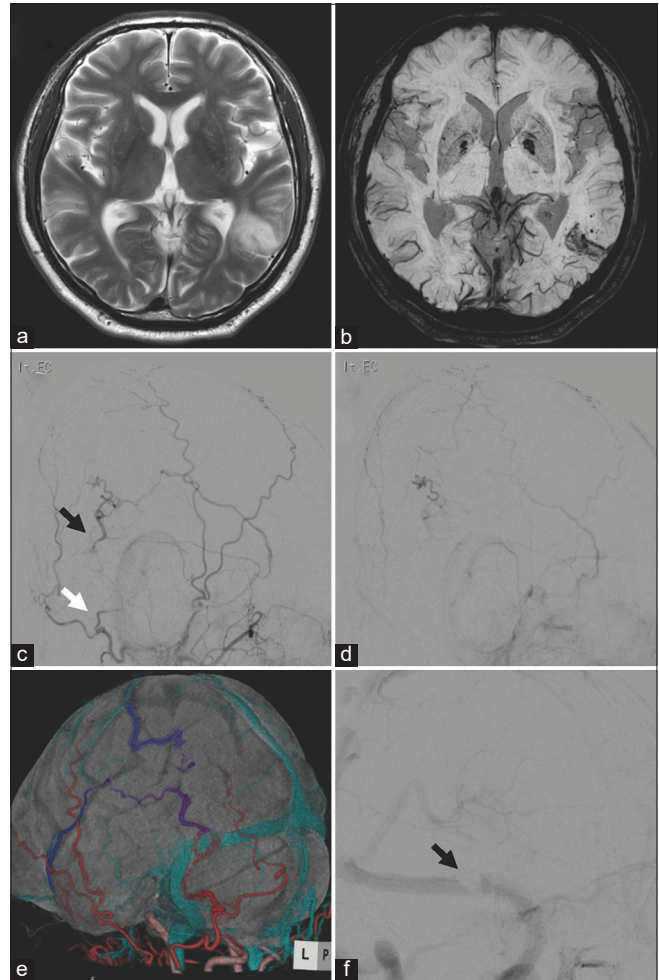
(a) T2-weighted magnetic resonance imaging (MRI) showing focal edema in the left temporal lobe. (b) Susceptibility-weighted imaging revealing microbleed in the same area. (c) Preoperative left external carotid artery angiography showing Borden Type III dural arteriovenous fistula (dAVF) in the left transverse sinus. White arrow indicates the feeding artery and black arrow indicates a shunting point. (d) Early venous phase of angiography demonstrating cortical venous reflux without the transverse sinus. (e) Fusion image of three-dimensional computed tomography angiography and MRI showing the detailed structure of the dAVF, consisting the occipital artery (red), cortical vein reflux (purple), and draining vein (blue). (f) Preoperative left internal carotid artery angiography showing sinus thrombosis in the left transverse sinus adjacent to the shunting point (f, black arrow).
